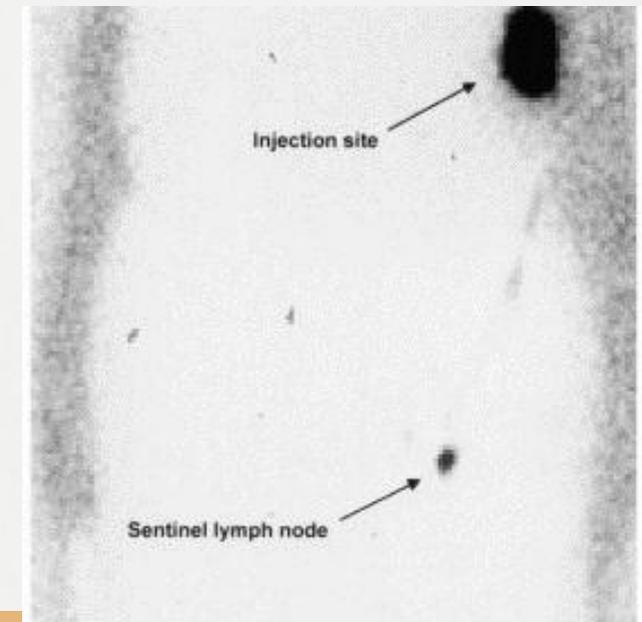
Lymphoscintigram of a patient with a primary melanoma in the left scapular region, demonstrating axillary nodal drainage and an interval sentinel lymph node (SLN) in the subcutaneous tissues of the back.
